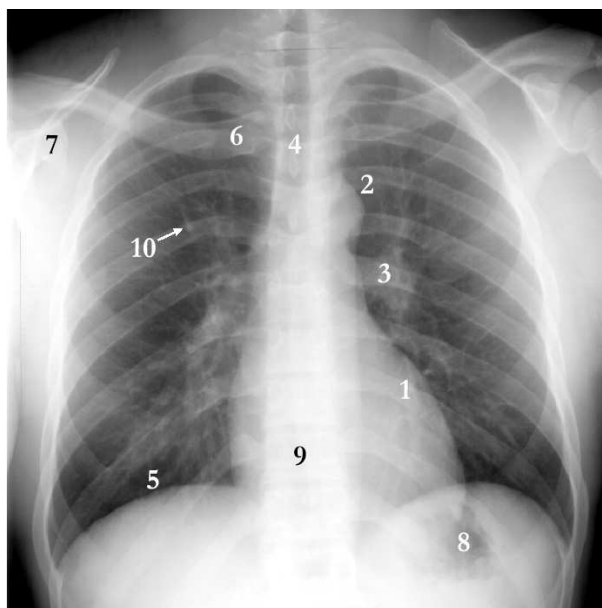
1) The heart. 2) The aortic arch where the aorta bends. 3) The (in the case left) hilum, where the arteries and veins enter the lung. 4) A darker vertical stripe indicates the trachea. 5) Below the lung field the diaphragm starts. 6) Clavicle. 7) Shoulder-blade. 8) Usually stomach gases can be seen in the left diaphragm. 9) If there is enough contrast in the mediastinum (the area projected between the lung fields) the spine may be visible. 10) A round dot like this is the shadow of a vessel that runs in the same direction as the X-rays.
